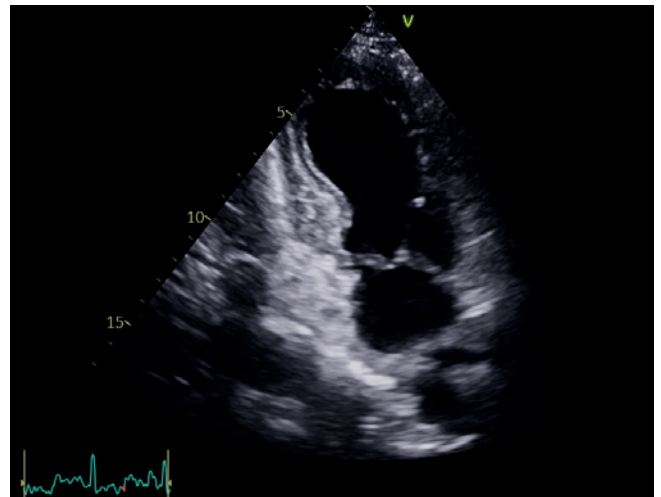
Apical 2 chamber image showing apical akinesia with preserved basal segments contraction suggestive of Takotsubo/stress cardiomyopathy.
